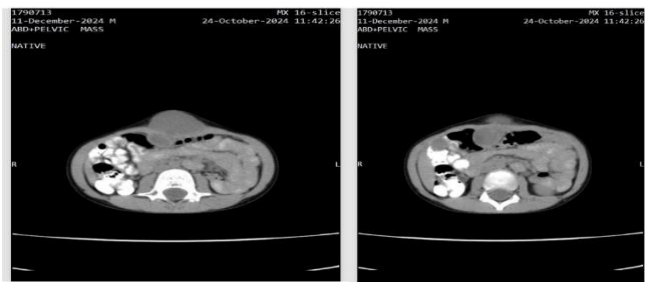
CT image showing the anterior abdominal wall cyst with communication to the liver cyst.
